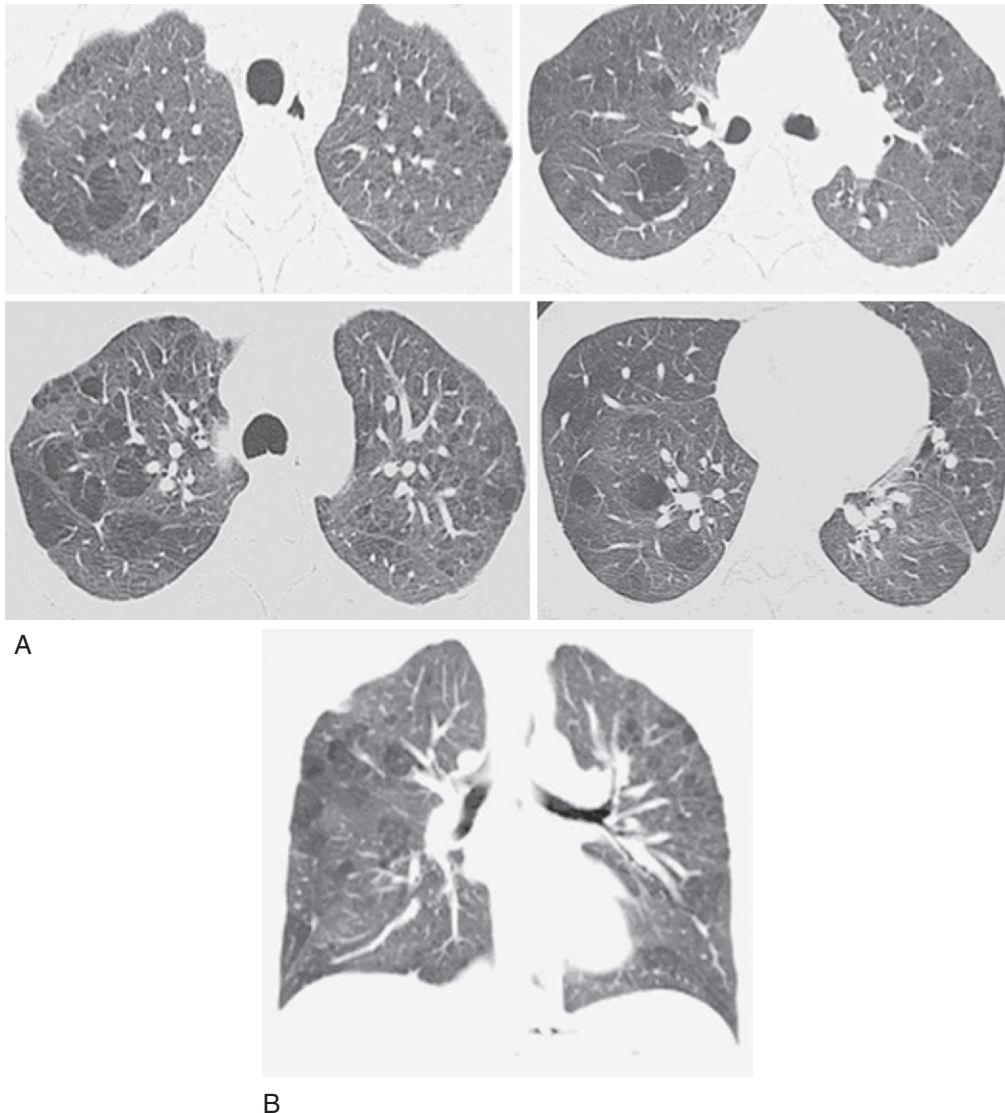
(A) High-resolution CT of the chest demonstrates asymmetric lobular air trapping with diminished vascularity shown in the lungs bilaterally from Swyer-James-Macleod syndrome. (B) Distribution of abnormality is better appreciated on the coronal reformatted image. (From Pipavath SN, Stern EJ. Imaging of small airway disease (SAD). *Radiol Clin North Am.* 2009;47:313.)
